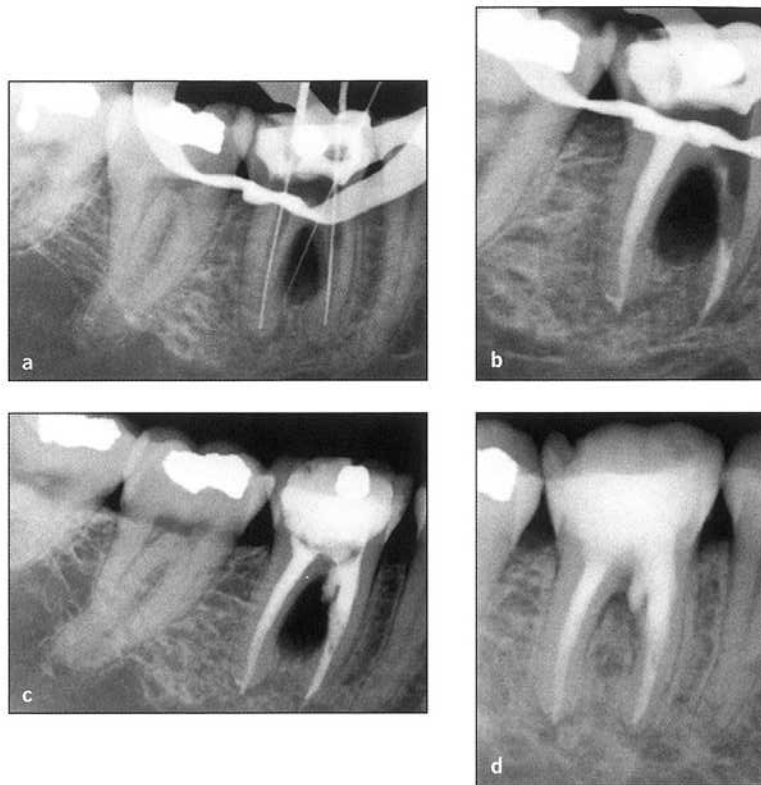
(a) Preoperative radiograph of a maxillary first molar with a furcation perforation and a large amount of gutta-percha extruded in the furcation. (b) Postoperative radiograph of the tooth after raising a buccal mucoperiosteal flap, preserving the coronal bone, curetting the furcation, and repairing the defect with MTA. (c) Postoperative radiograph of the tooth after 1 year. (d) Postoperative radiograph of the tooth after 3 years.
